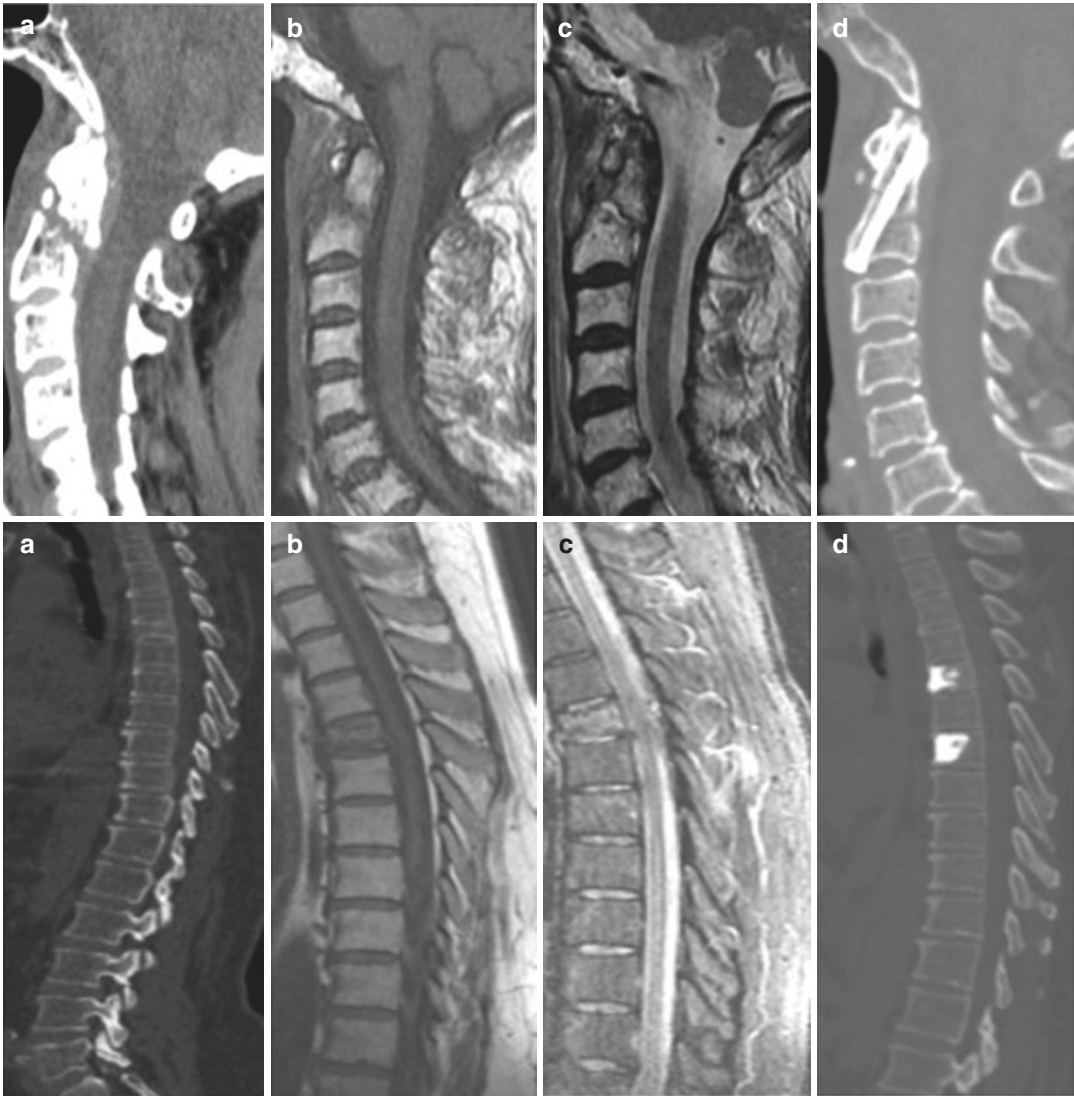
Top row:* Odontoid fracture in an 80-year-old woman. The patient presented with neck pain after falling. Her neurological examination was normal. Cervical T1- and T2-weighted sagittal MRIs and cervical sagittal CT scan examinations show the odontoid fracture in the second cervical spine (a–c). Odontoid fracture was fixed with screw. Control CT scan was normal (d). The patient was
